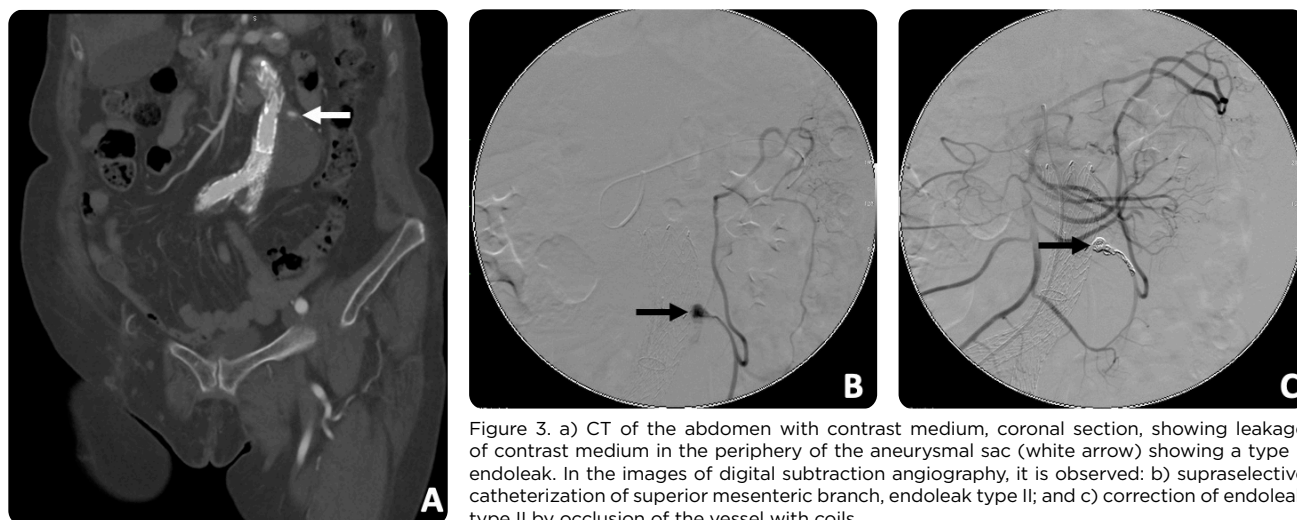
a) CT of the abdomen with contrast medium, coronal section, showing leakage of contrast medium in the periphery of the aneurysmal sac (white arrow) showing a type II endoleak. In the images of digital subtraction angiography, it is observed: b) supraselective catheterization of superior mesenteric branch, endoleak type II; and c) correction of endoleak type II by occlusion of the vessel with coils.
